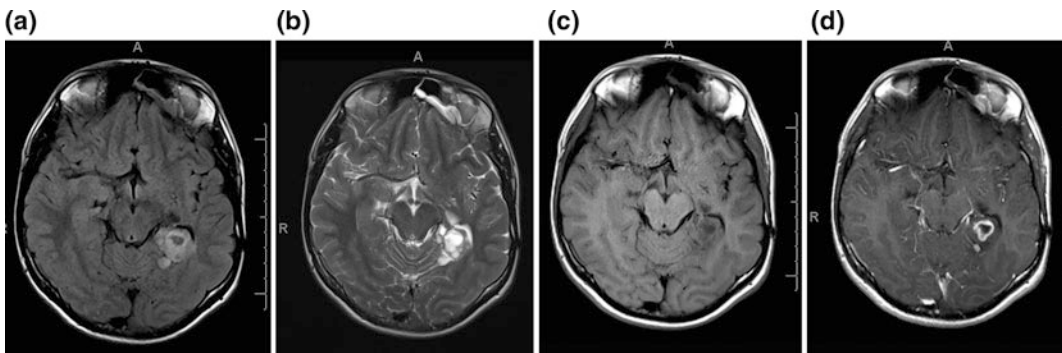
Axial FLAIR (a), T2-weighted (b), pre-contrast (c), and post-contrast T1-weighted MRI (d) demonstrating solid and cystic mass in the left
